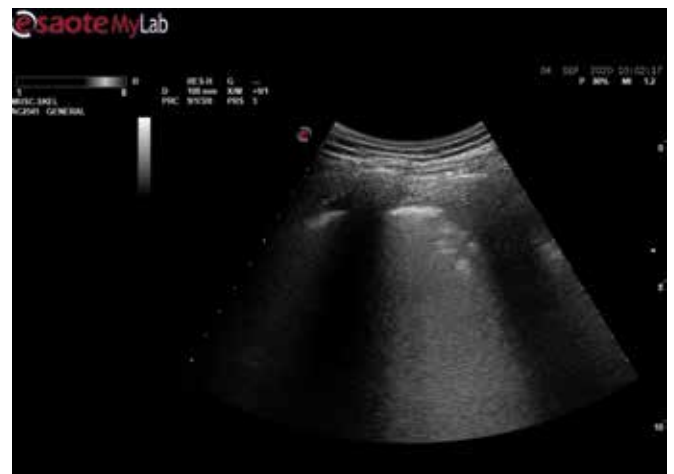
Lung ultrasound shows small subpleural consolidation
